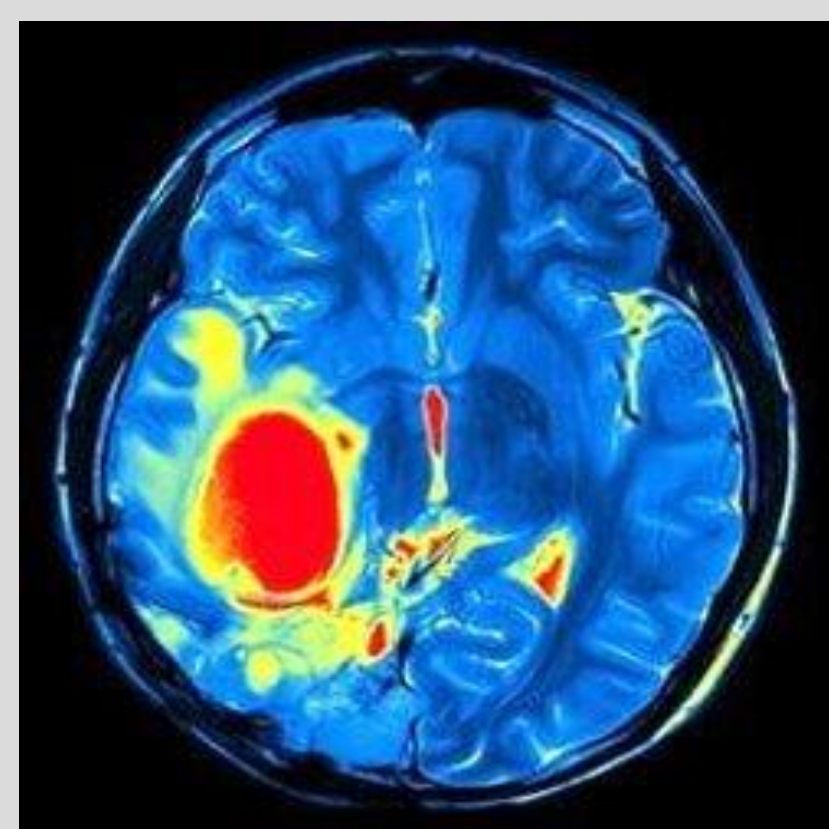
MRI demonstrates a tumor in the posterior left temporal lobe
